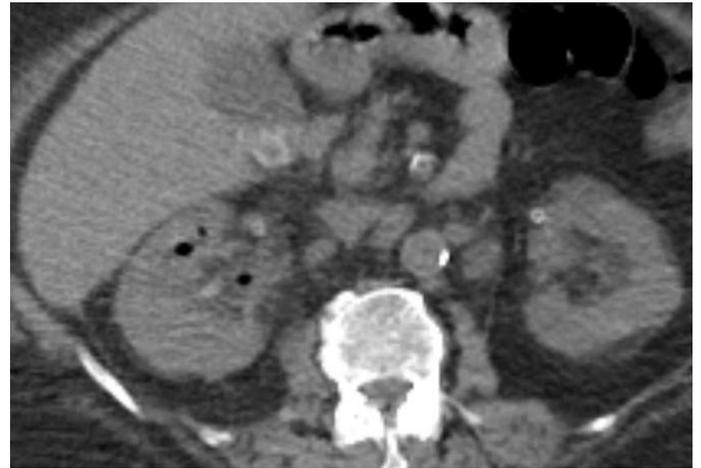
First abdominal CT scan of the patient
